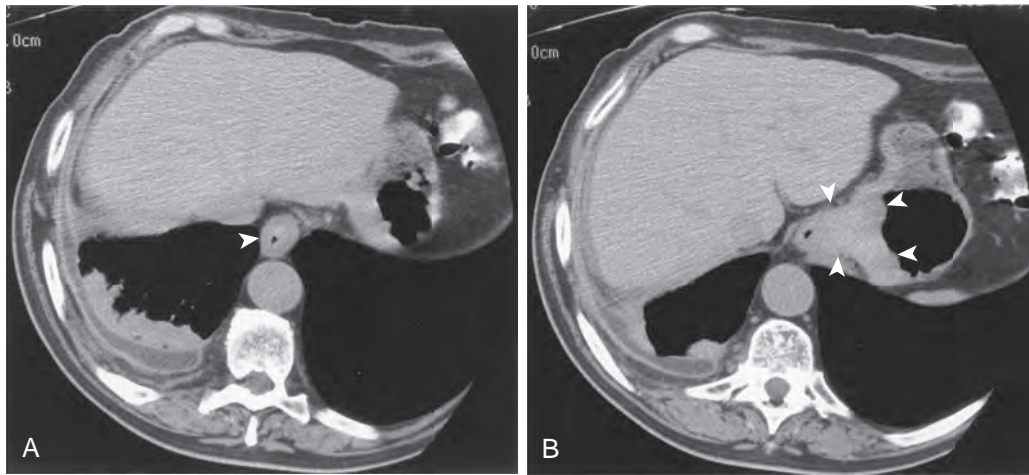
Secondary achalasia on CT. A. CT scan shows asymmetric thickening of the esophageal wall (arrowhead) in the distal esophagus at the level of beaklike narrowing seen on a prior barium study (not shown). B. Another CT image more caudally shows an asymmetric soft tissue mass (arrowheads) at the gastroesophageal junction protruding into the medial aspect of the gas-filled fundus. This patient had a carcinoma of the cardia causing secondary achalasia.
